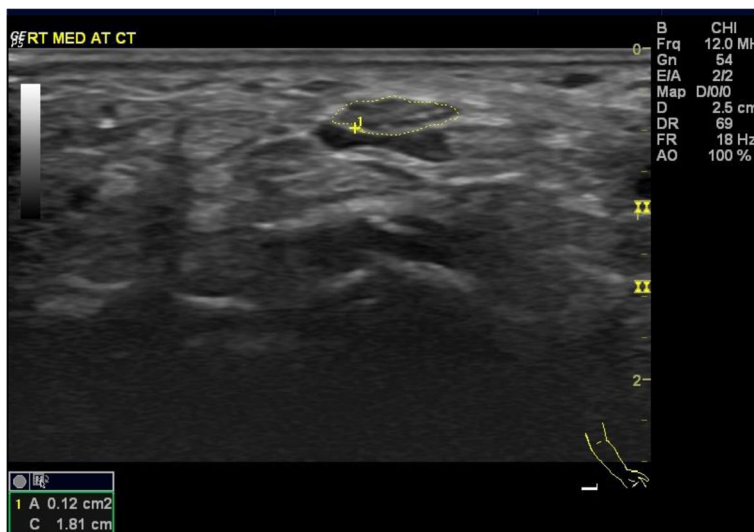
Patient with disease activity score (DAS28) = 4.8 showing gray scale ultrasound of right median nerve at the level of the wrist with the cross-sectional area (CSA) (12mm²)
